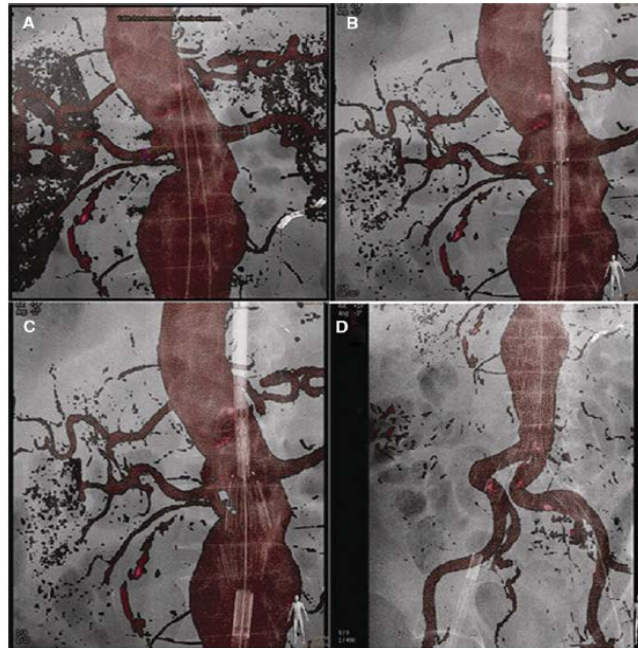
Stent–graft deployment for infrarenal abdominal aortic aneurysm using preoperative CTA as a 3D roadmap overlaid on live fluoroscopy [11]
